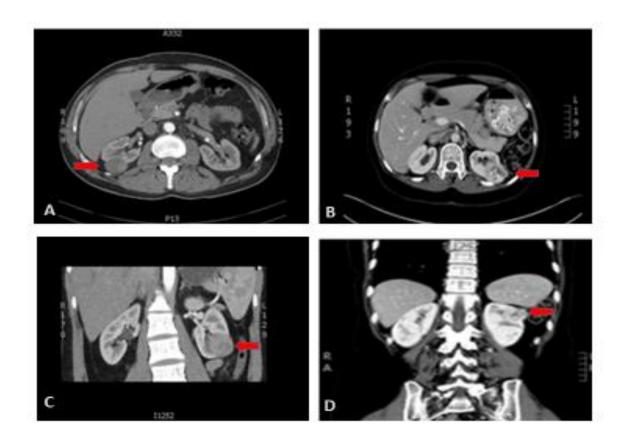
CT scan of renal tumourA. Axial CT scan (corticomedullary phase) of right chRCC; B. Axial CT scan (nephrographic phase) of left RO; C. Coronal CT scan (corticomedullary phase) of left chRCC; D. Coronal CT scan (nephrographic phase) of left RO (renal tumours shown with red arrows)
